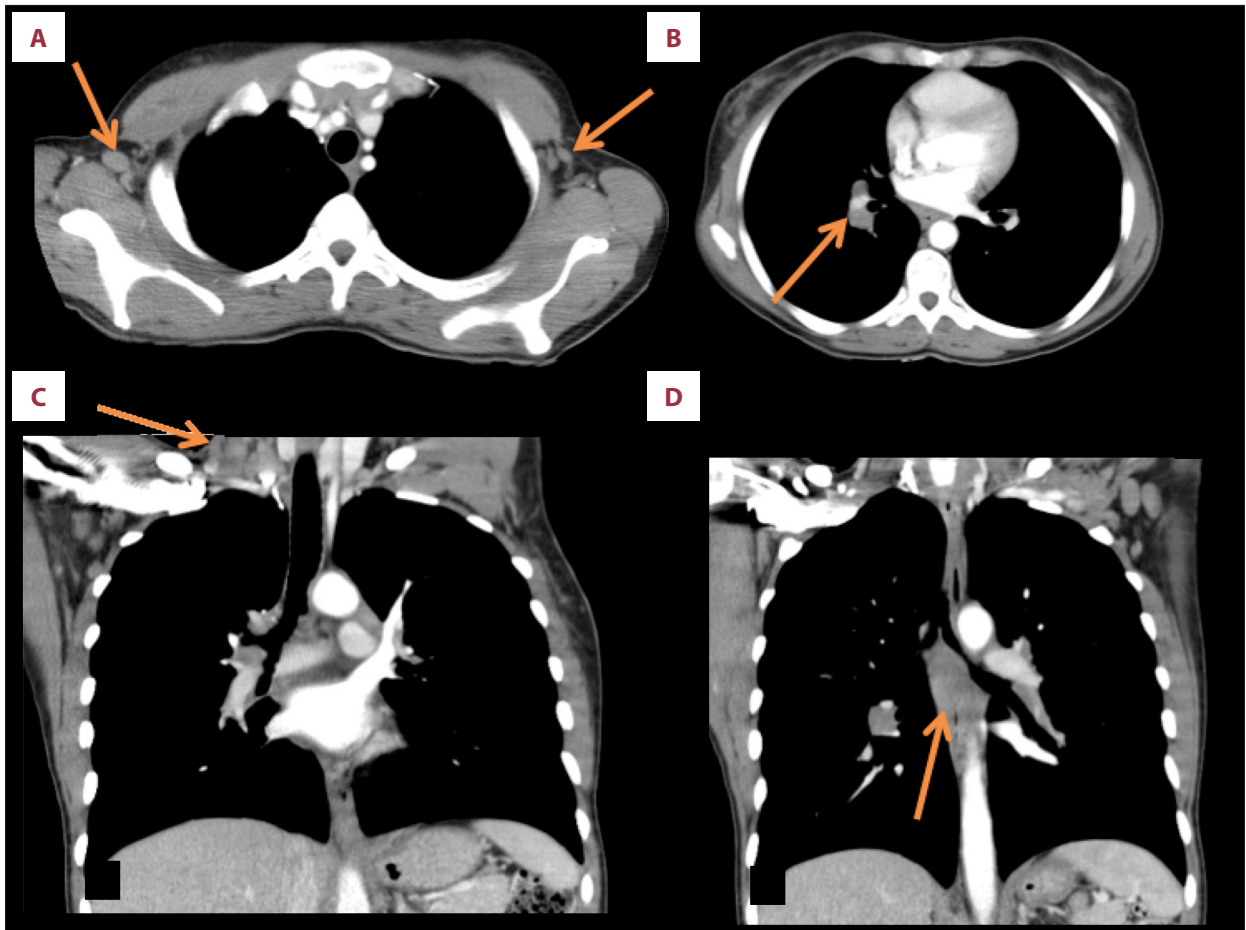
One week after start of treatment, selected axial (A, B) and coronal (C, D) contrast-enhanced CT scan of the chest, demonstrating significant reduction in size of the right supraclavicular (arrow in C), bilateral axillary, hilar, and subcarinal lymphadenopathy, indicating a favorable response to treatment.
